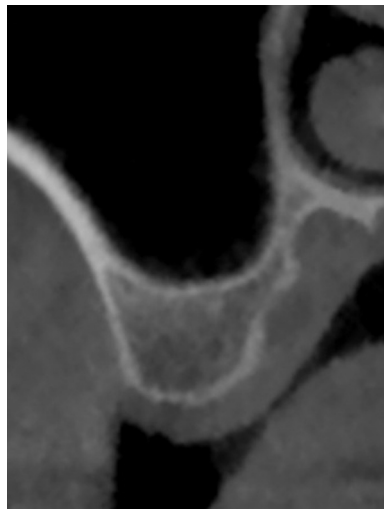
Transverse view of the CBCT scan of a sinus in which the posterior superior alveolar artery was not detected.
